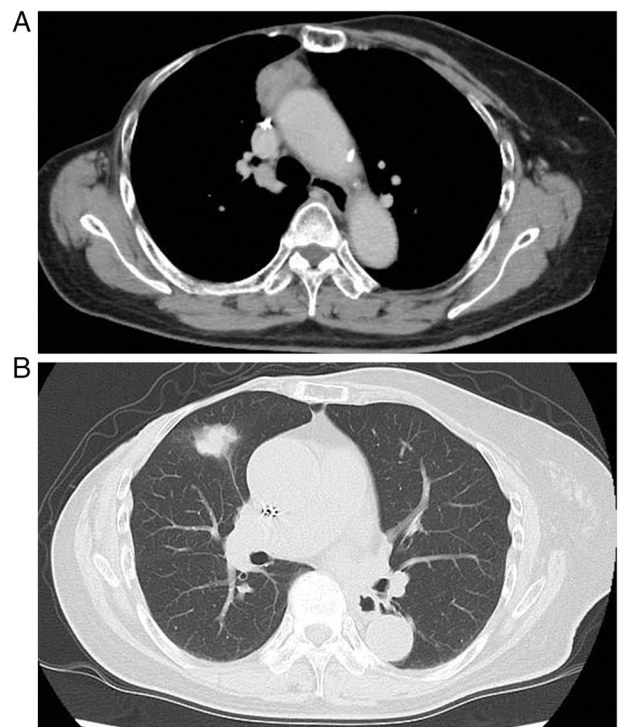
Preoperative CT. CT images show (A) anterior mediastinal tumor and (B) pulmonary nodule. CT, computed tomography.
